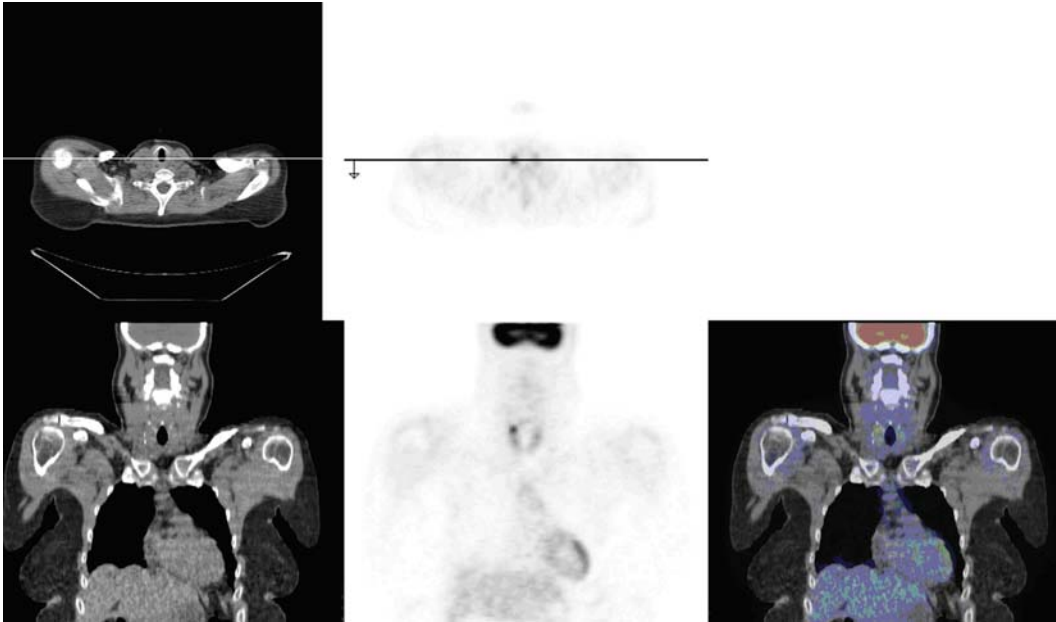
PET/CT fusion image of right superior parathyroid.
